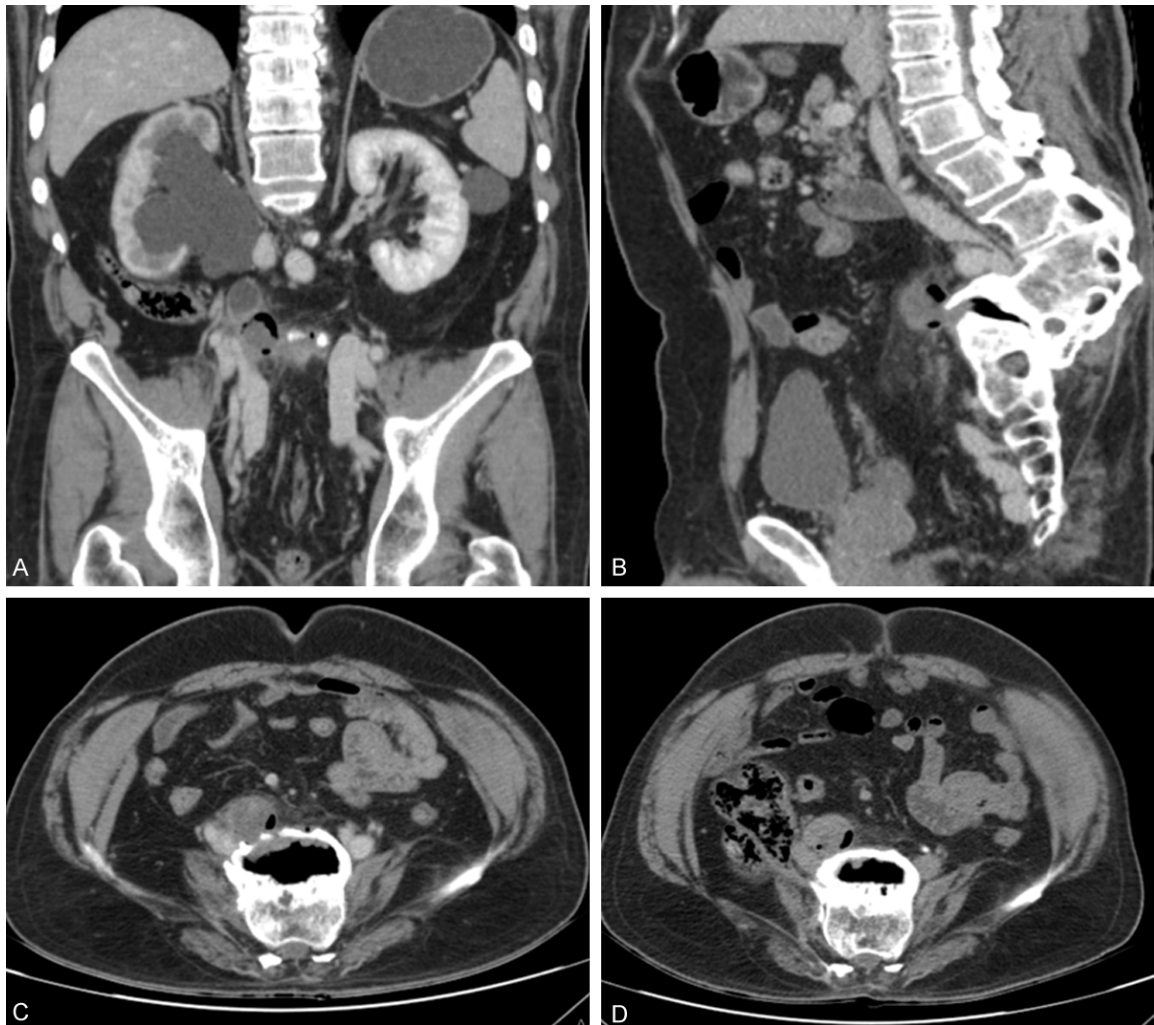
Abdominopelvic CT scan with contrast. In the portovenous phase, (A) coronal images show severe stasis of the right kidney with an intra-ureteric mass lesion in the midpart of the ureter; (B) sagittal images show Gibbus deformity of lower lumbar spines with degenerative changes and a vacuum phenomenon; and (C) direct invasion of spondylitis to the right ureter with tuberculoma within the ureter. In the delayed phase, (D) the right kidney's excretion is delayed due to obstructive uropathy.
